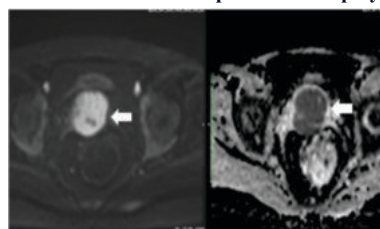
Same case of large solid Cervical carcinoma showing restricted diffusion (DWI first image & ADC second axial image)
